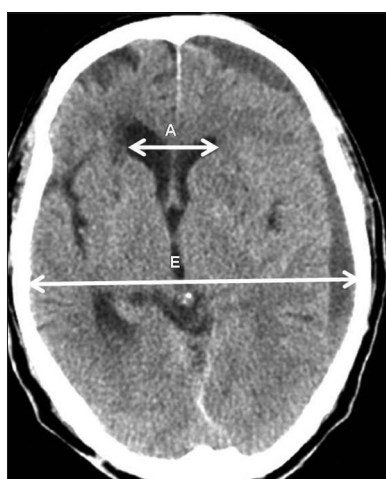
Axial computed tomography scan, demonstrating measurement technique for Evans' index as the linear ratio of the total width of the frontal horns of the cerebral lateral ventricles (A) to the maximum inner diameter of the skull at the level of the measurement (E).
